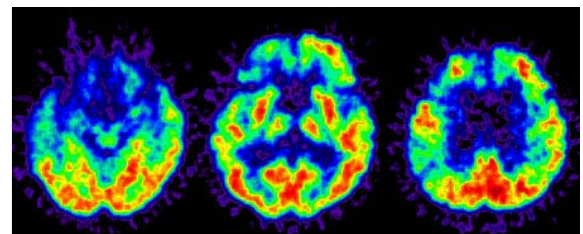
Typical FDG-PET image of a patient with FTD. This case is a 62-year-old female whose MMSE score was 25.
